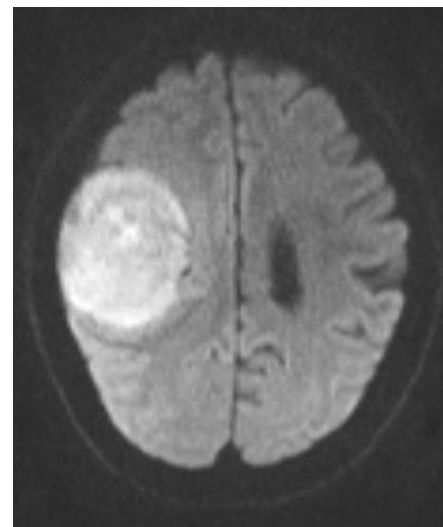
DWI restricted diffusion
